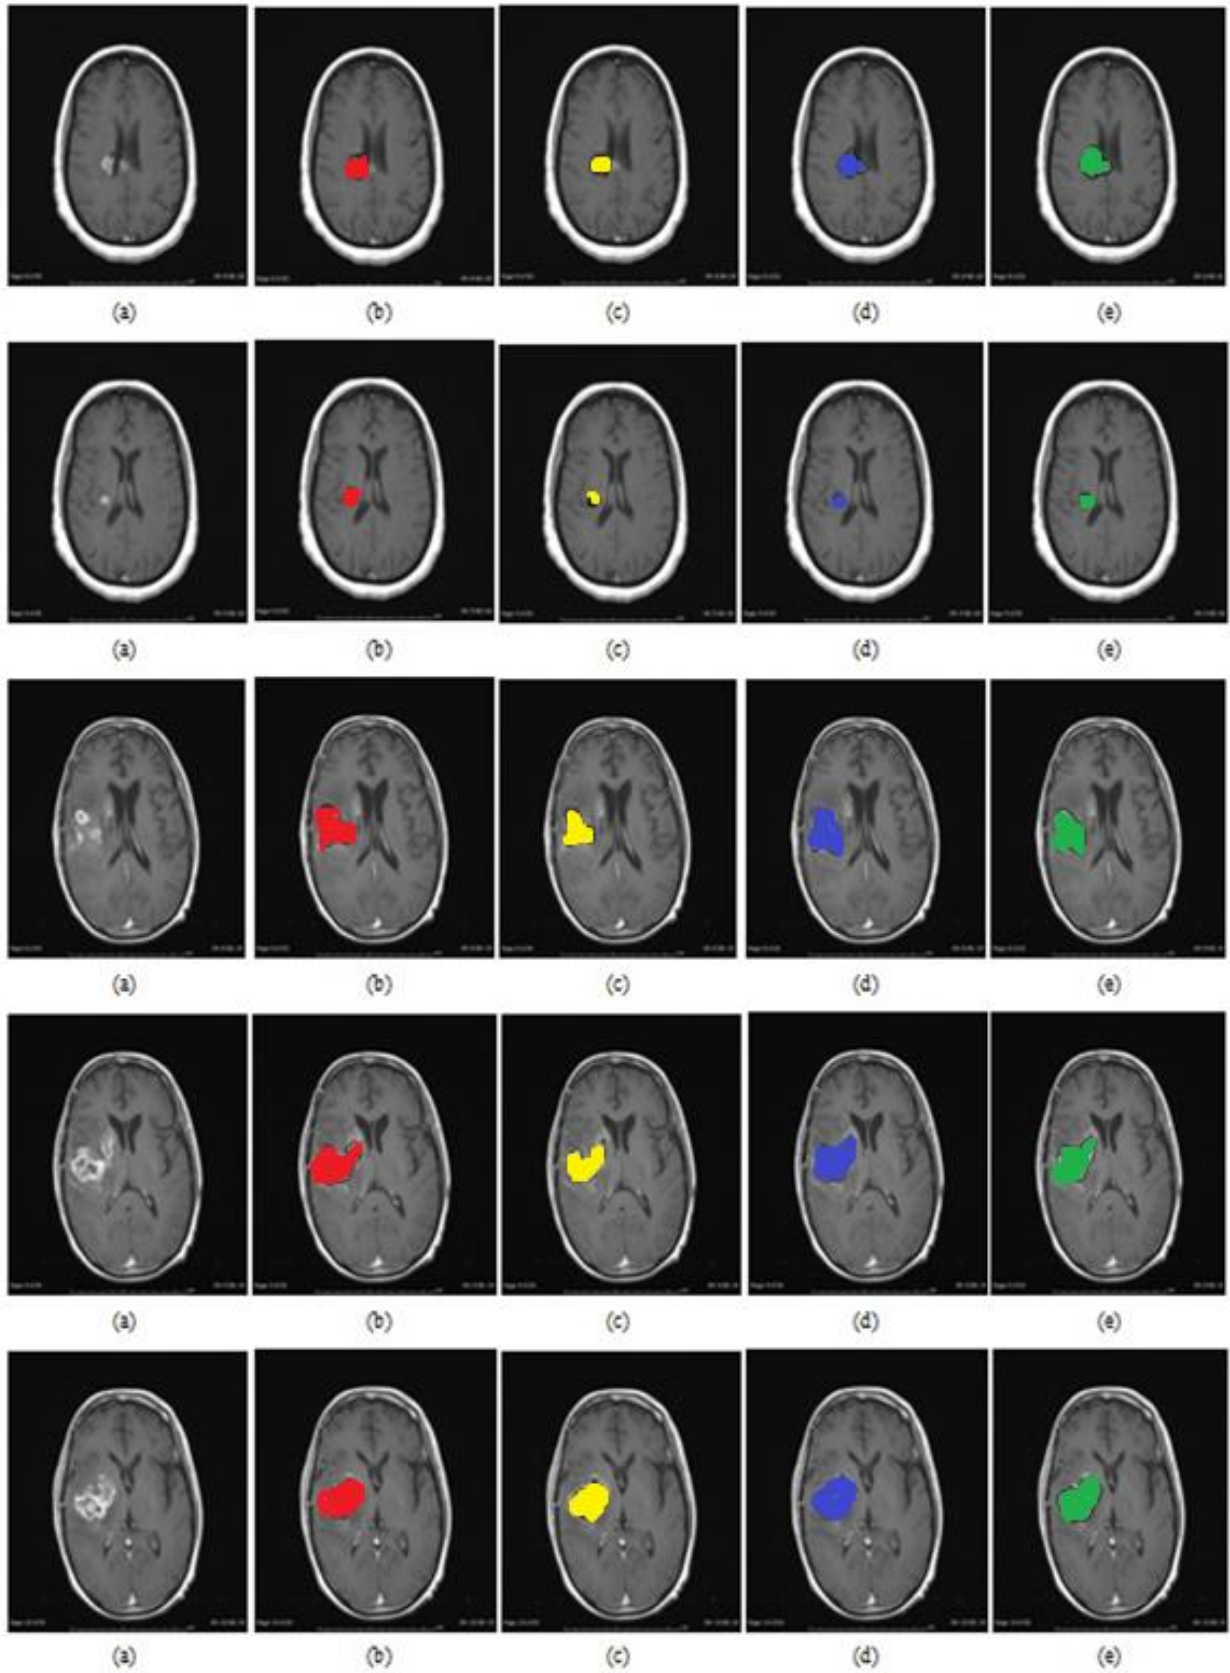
(a) Input MRI image, Tumor mapping with (b) FCM (c) IFCM (d) IIFCM (e)
